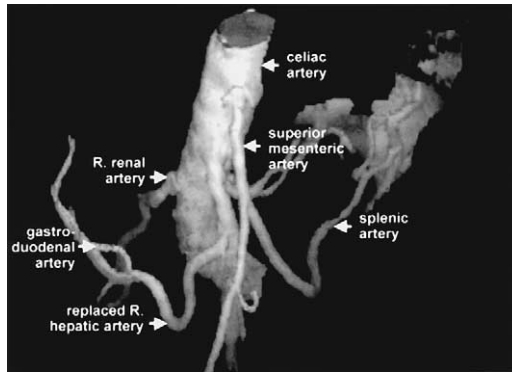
CT angiogram showing three-dimensional image of hepatic arterial anatomy. R, right.
